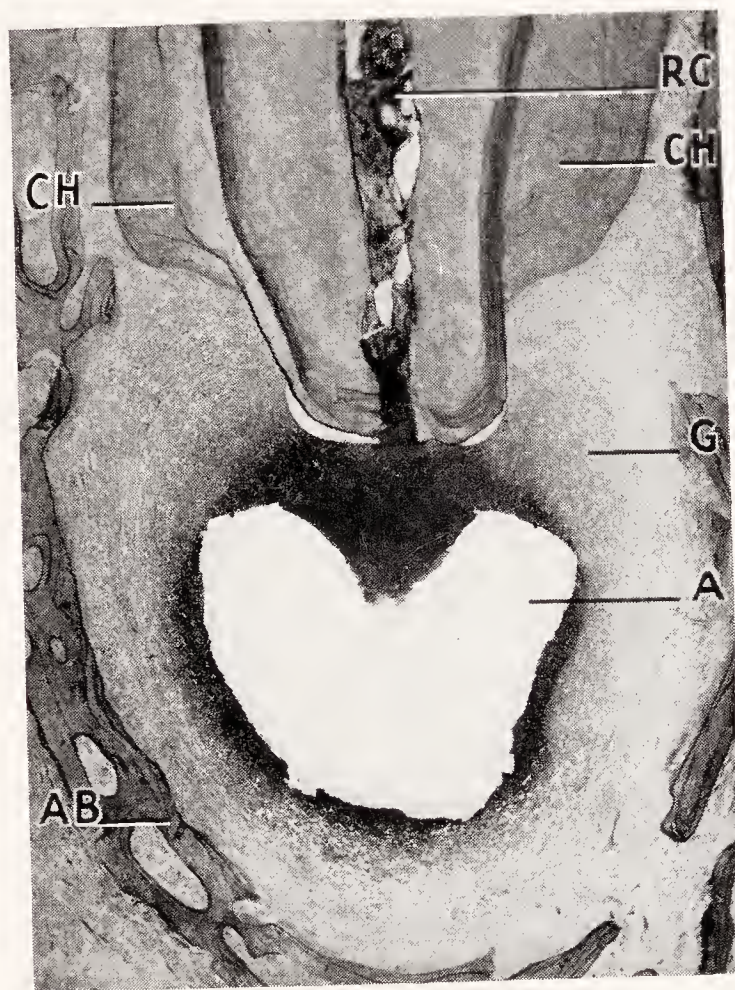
Hyperplasia of cementum in the proximity of chronic periapical inflammation. Upper bicuspid. *CH*, cementum hyperplasia; *RC*, root canal containing necrotic pulp remnants; *G*, granuloma; *A*, abscess cavity containing a purulent exudate; *AB*, alveolar bone. (Courtesy of Wm. G. Skillen.)
